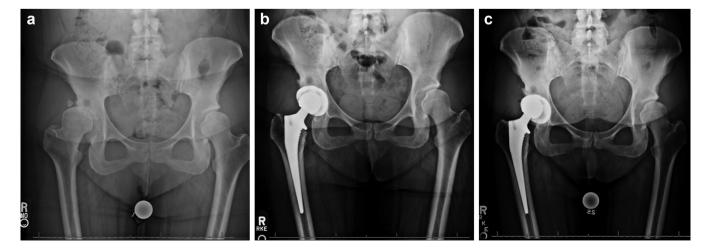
(a) Preoperative and (b) postoperative anteroposterior (AP) pelvis radiographs and (c) AP pelvis radiograph showing liner disassociation with asymmetrical position of the femoral head within the acetabular component for case 1.
